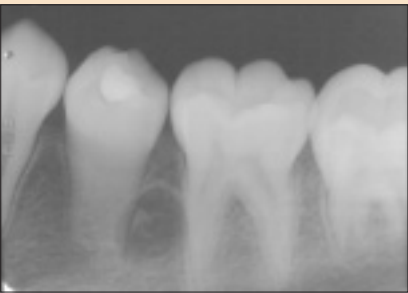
Periapical radiograph of tooth 35, obtained 8 months after initiation of apexification, shows a calcifying supernumerary premolar.
